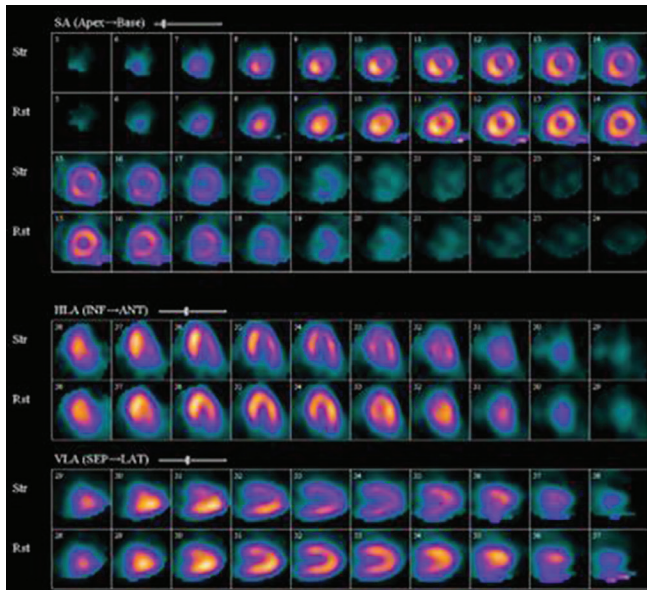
Sample SPECT-MPI image with CAD.
